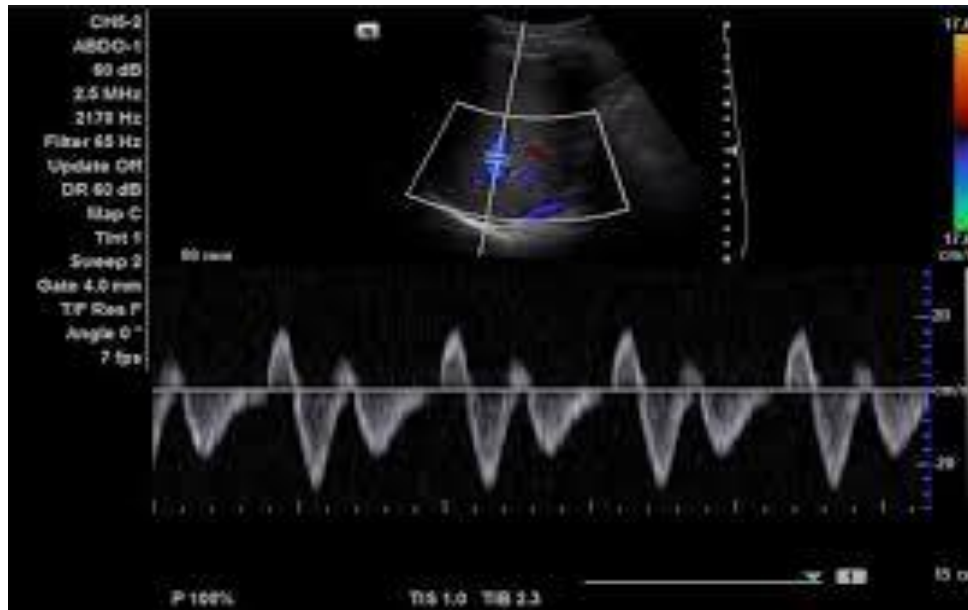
Ultrasound Doppler of normal liver (57)
